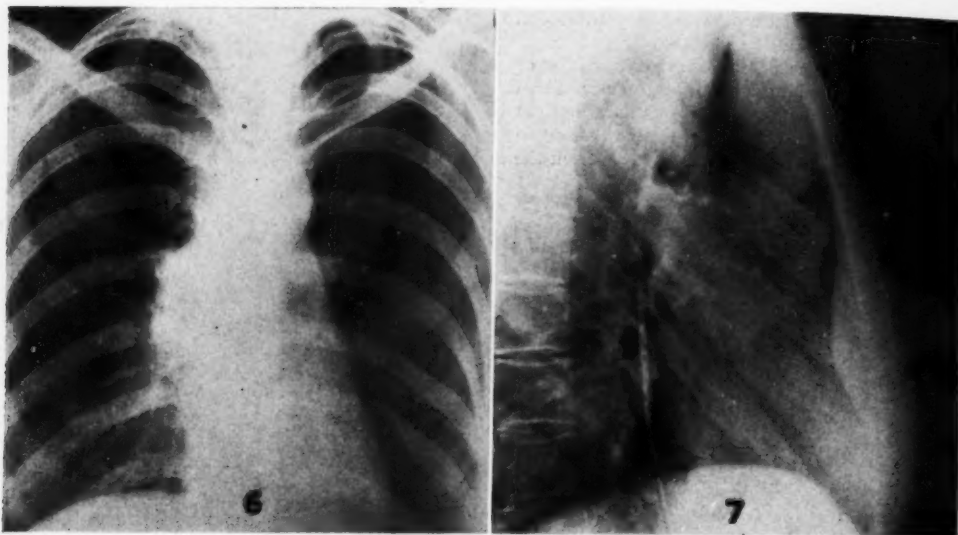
Case 1: After several courses of x-ray therapy, the retrosternal mass has disappeared; extensive involvement of sternum is visible. Nov. 22, 1943.
